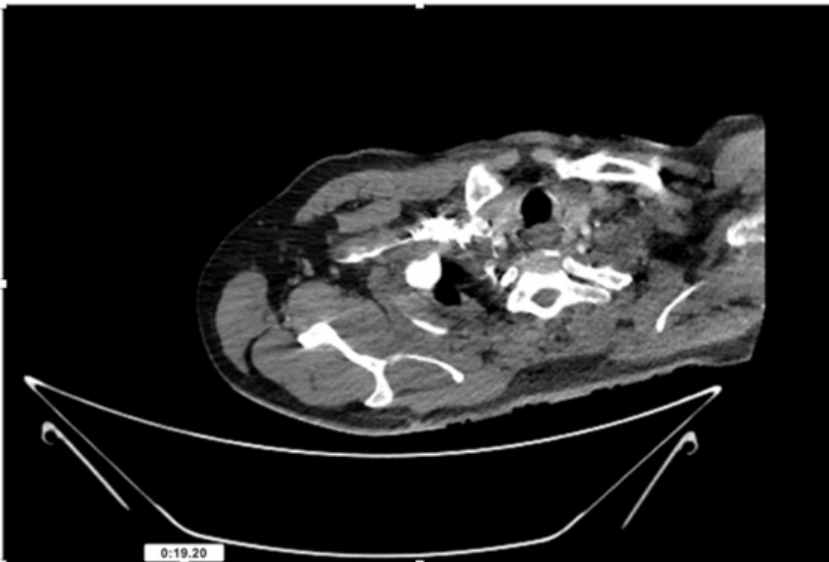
CT Angiogram at neck showing brachio-cephalic trunk, common carotid artery and narrow right subclavian artery.
